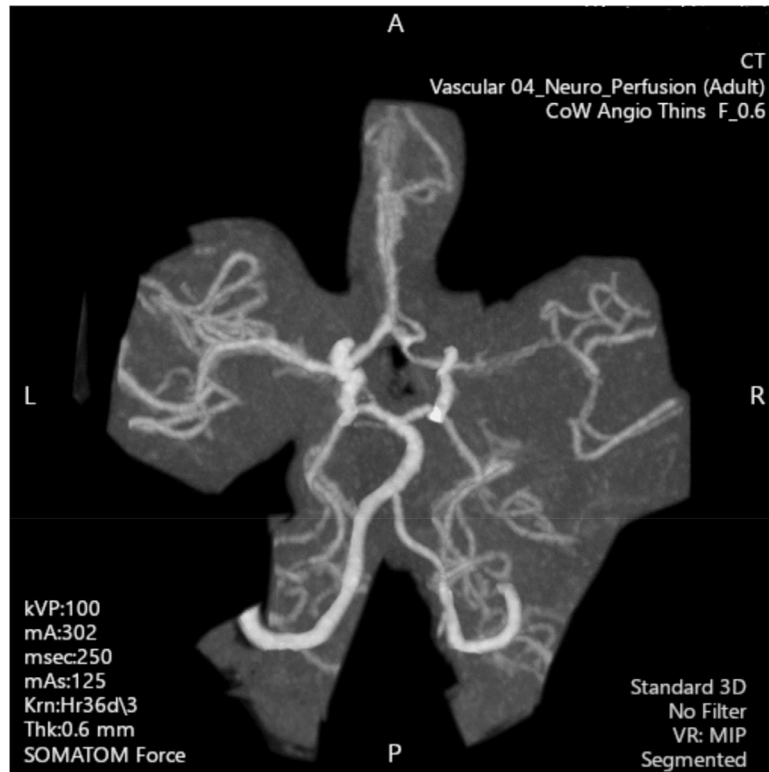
CT angiogram virtual reconstruction of circle of Willis using maximum intensity projection. Note the asymmetric narrowing of the right Internal carotid artery and right middle cerebral artery M1 and M2 segments compared to left. Evidence of left sided focal stenosis at the superior cavernous segment of left ICA is not visualized here.
